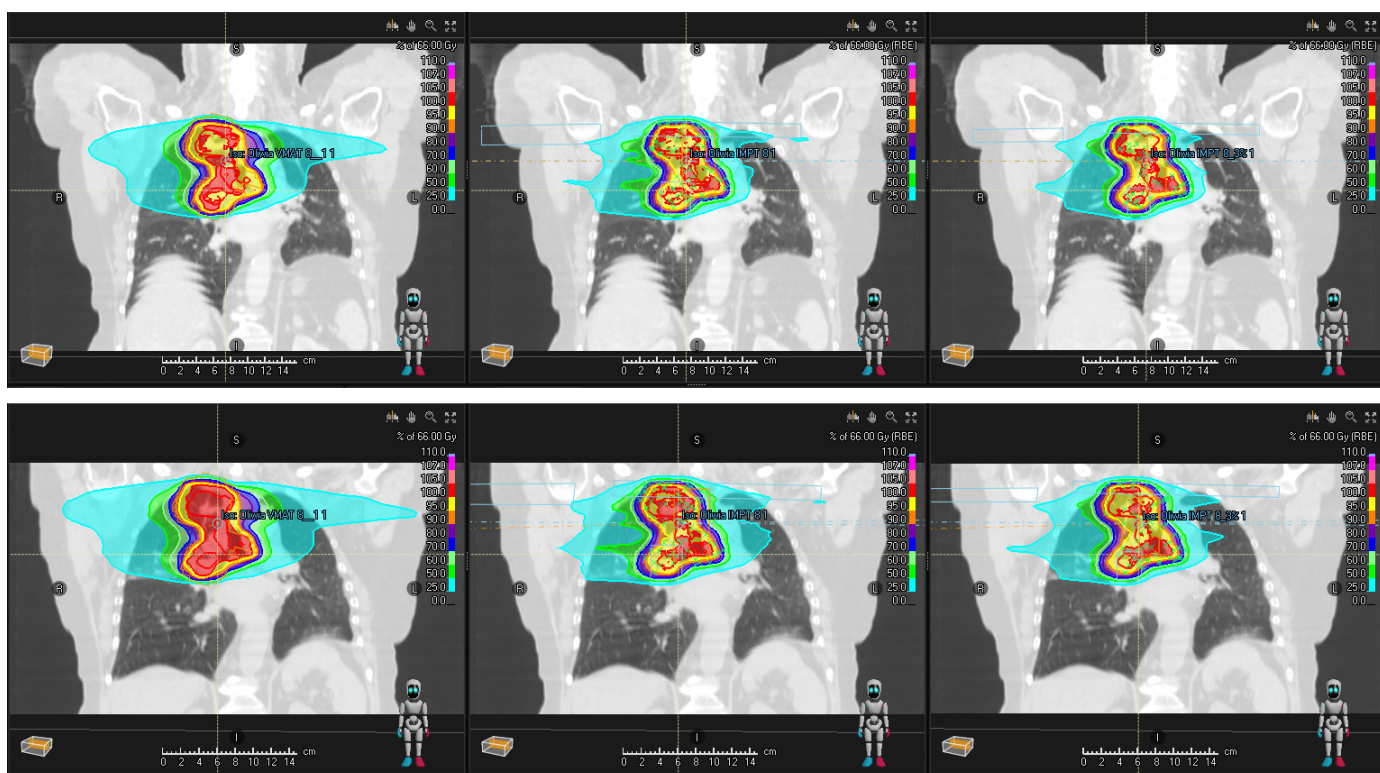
Dose distribution for patient 8 showing varying conformity. Images are from the three treatment plans, VMAT on the left side, IMPT_{4.5%} in the middle, and IMPT_{3%} on the right side. The CT 2 version of each is included below. The ICTVu is delineated in red.
